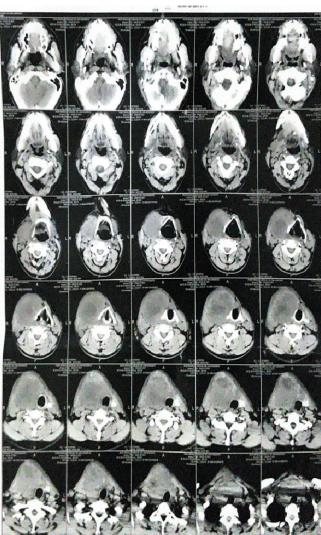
Magnetic resonance imaging showing anatomical distortion
